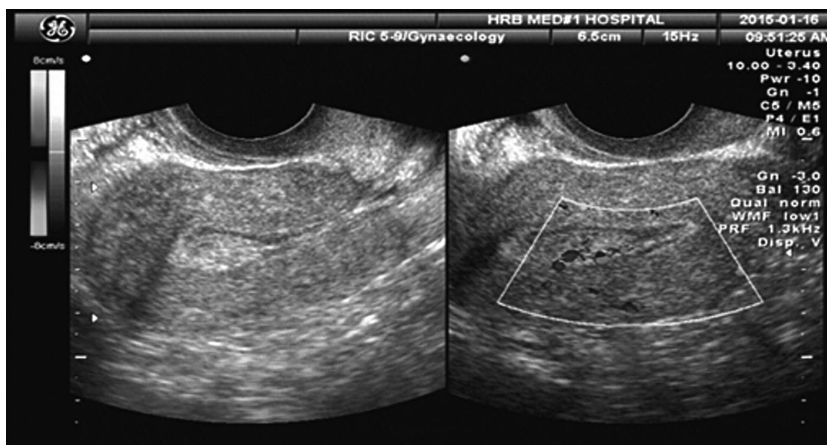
Endometrial polyps by transvaginal ultrasound and color Doppler flow imaging.
